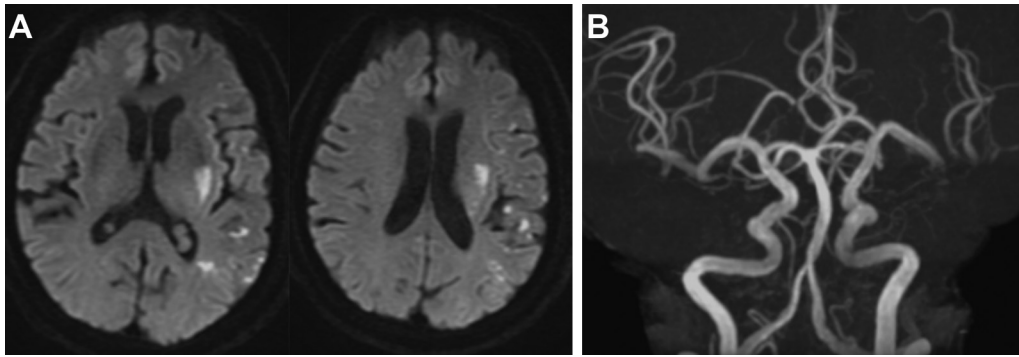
Case 1. Postoperative MRI-DWI (A)/MRA (B). (A) In the left cerebral hemisphere, the hyperintensity area was slightly enlarged in comparison with the preoperative area. (B) Stenosis of the left middle cerebral artery remained, but arteries distal to the site of stenosis were visualized. DWI: diffusion-weighted imaging; MRA: magnetic resonance angiography; MRI: magnetic resonance imaging
